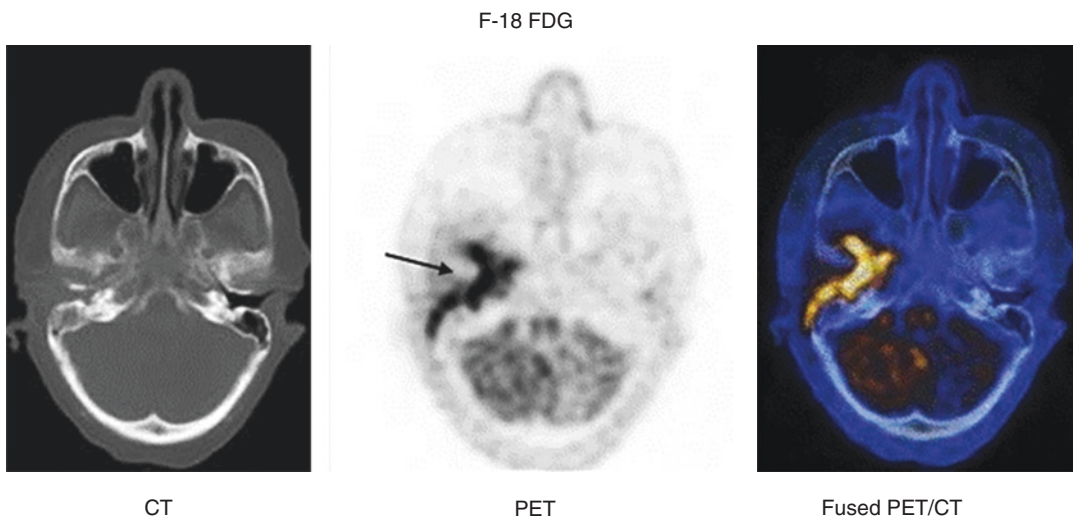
Selected cuts of F-18 FDG study for a 73-year-old female with severe external otitis known to be due to *Pseudomonas aeruginosa* for assessment of bone involvement. There is intense metabolic activity (arrow) along the external auditory canal with extension to the petrous bone.
